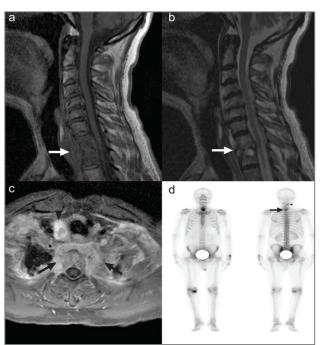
a–d. T1 and T2 vertebra corpuses and paravertebral soft tissue mass shows hypointensity on sagittal unenhanced T1-weighted image (a)and slight, heterogenous hyperintensity on T2-weighted image (b) (white arrows). Signal intensity of narrowed, irregular intervertebral disc space is similar to neighbouring vertebral end-plates. Axial contrast-enhanced, fat-saturated T1-weighted image(c)demonstrates hyperintense nodular lesion in right lobe of thyroid (black arrowhead) and pathologic contrast-enhancement in vertebrae corpuses and paravertebral soft tissues (black arrows). Whole-body BS (d) shows a focal, increased uptake in soft tissue of middle cervical region on right side (black arrowhead) and a diffuse, pathological, increased uptake in T1–2 vertebrae (black arrow).
